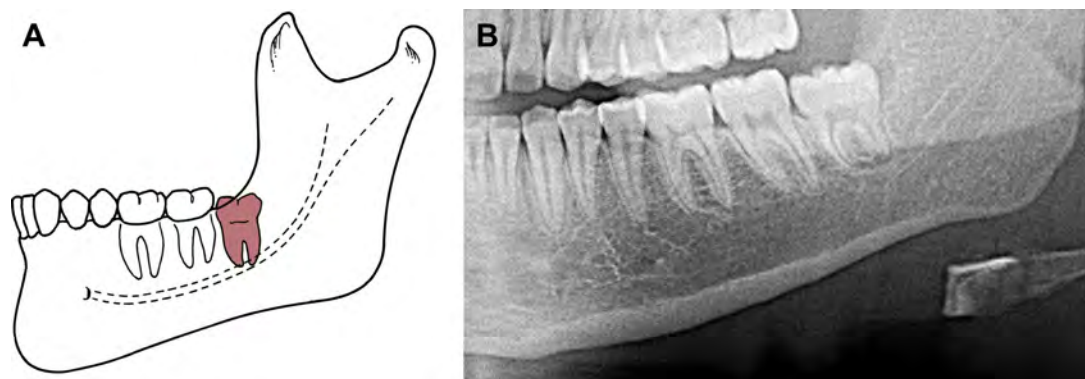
(A) Vertical mandibular impaction—second most common mandibular third molar impaction. (B) Radiograph of vertical impacted mandibular third molar. ([A] Adapted from Hupp JR, Ellis E III, Tucker MR, editors. Contemporary oral and maxillofacial surgery. 5th edition. St. Louis: Mosby Elsevier; 2008; with permission. Modified by Ion Syrbu.)
